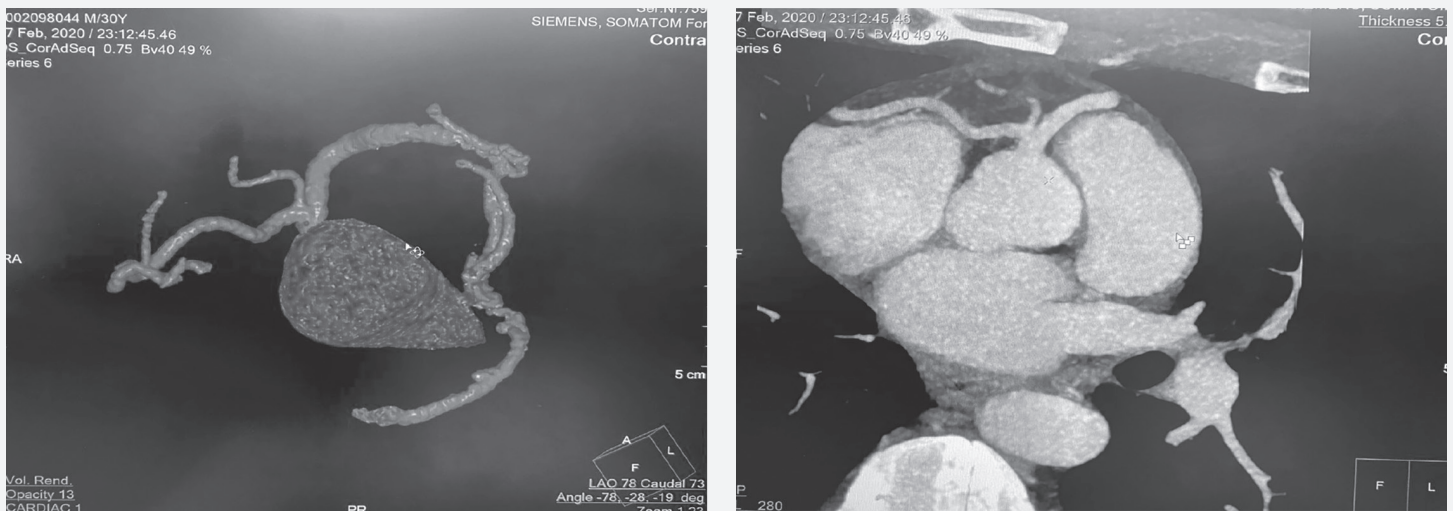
Shows the CT coronary angiogram (right) with the 3D reconstruction of the coronary arteries (left)
